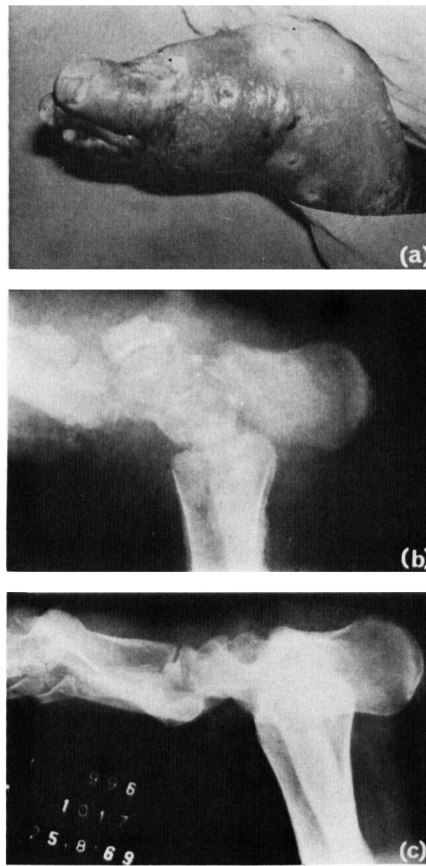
(a). External view on admission of foot shows multiple discharging sinuses; (b) radiograph on admission shows osteomyelitis and disintegration; (c) radiograph some 12 months later shows bone healing well advanced.
